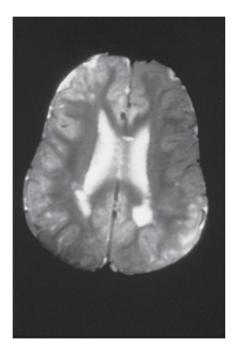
MRI of the brain of SR, a four-year-old patient with MSD. Moderately extensive high T_2 changes in the subcortical white matter were present bilaterally.
